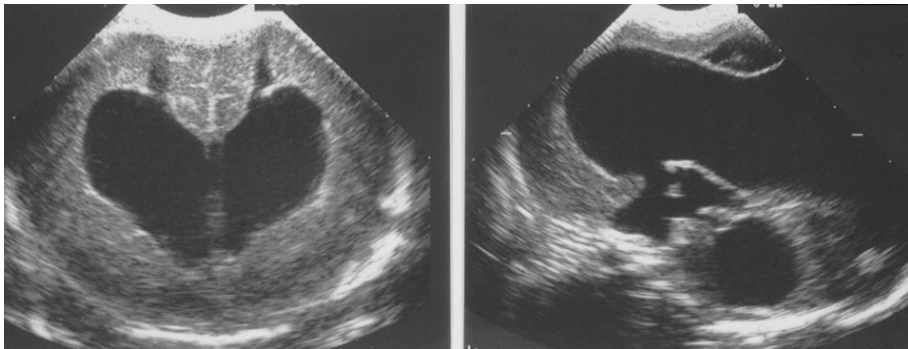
Ultrasound, coronal view (left), showing needle tracks following bilateral ventricular taps. The mid sagittal view (right), shows a very dilated third and fourth ventricle, suggesting outflow obstruction at the level of the foramina of Luschka and Magendie
